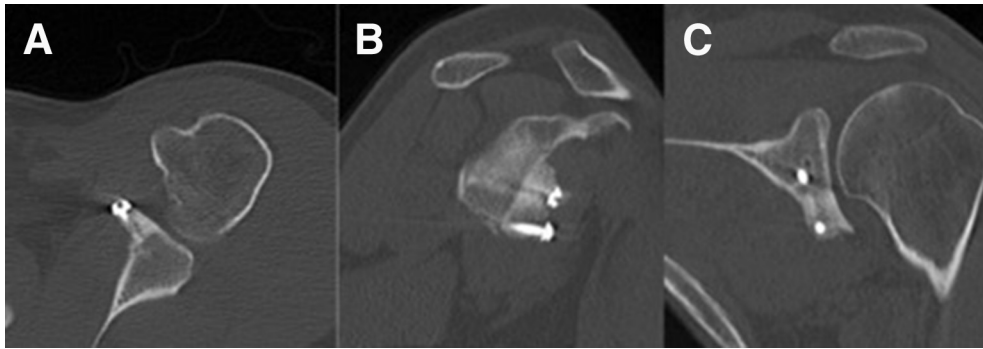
Postoperative computed tomography scan of the left shoulder taken approximately 2.5 years after distal tibia allograft reconstruction of the left glenoid showing excellent graft incorporation without evidence of lysis: (A) axial, (B) sagittal, and (C) coronal views.
